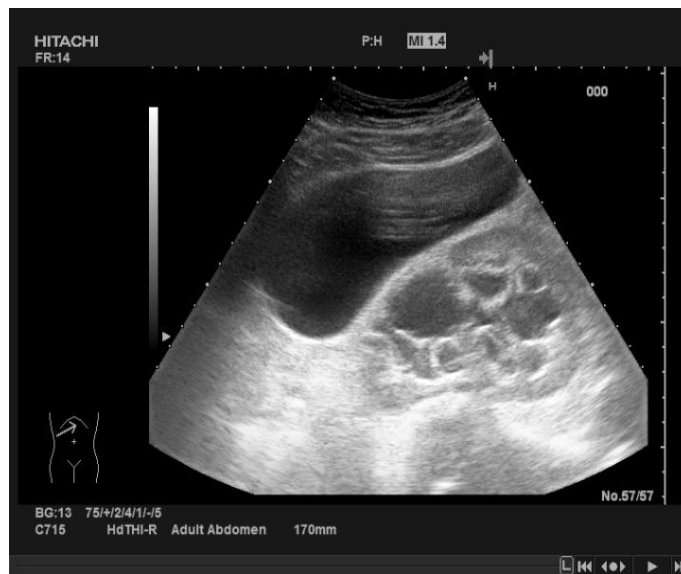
Ultrasound abdominal image.
